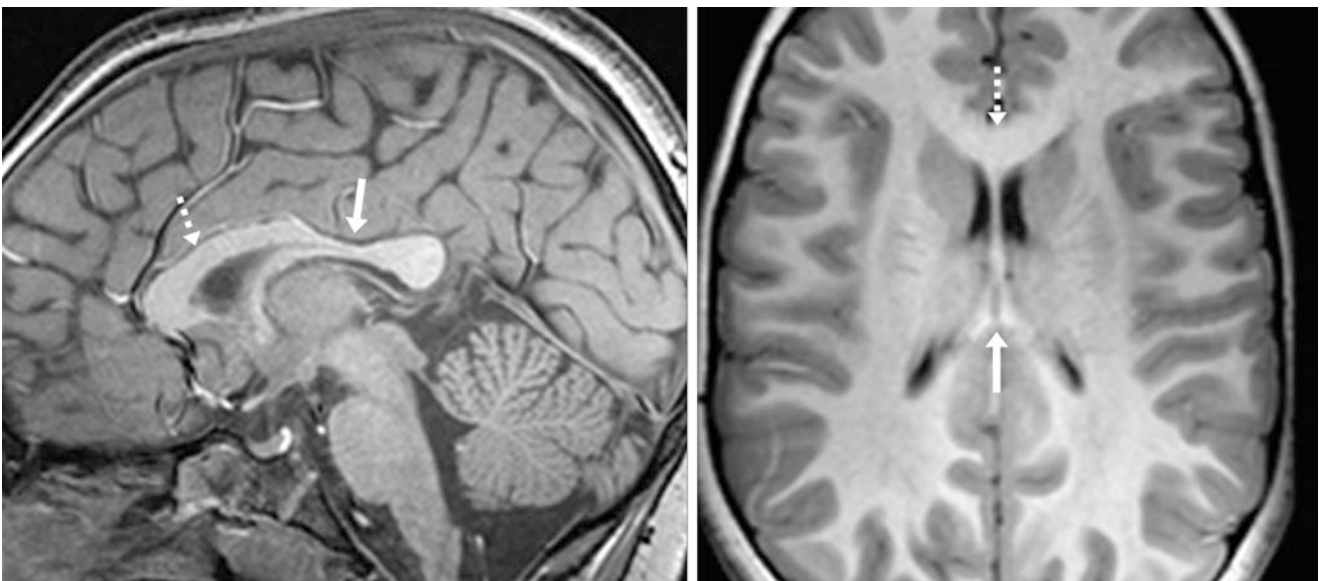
A 4 year old with an otherwise negative 3T MRI obtained for a behavioral disorder. It depicted a normal, moderately thin callosal isthmus on a midline sagittal T1WI (arrows, *left*). An axial T1WI (*right*) through the isthmus demonstrated the disparate thickness of the isthmus relative to the anterior body (dashed arrows)
